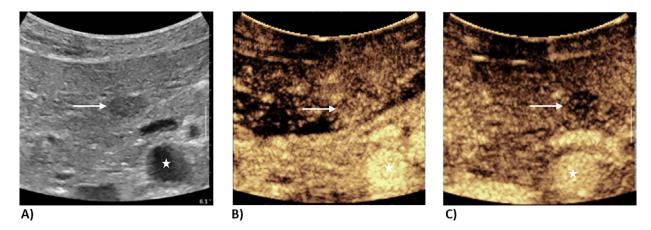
Contrast-enhanced ultrasound (CEUS) of one of the hepatic lesions (white arrow). (A) Gray scale image with hypoechogenic lesion in liver segment III; (B) late arterial phase showing contrast enhancement of the lesion with venous wash-out in (C). Please note contrast enhancement of the aorta as a reference to recognize the arterial and the venous phase (asterisk).
